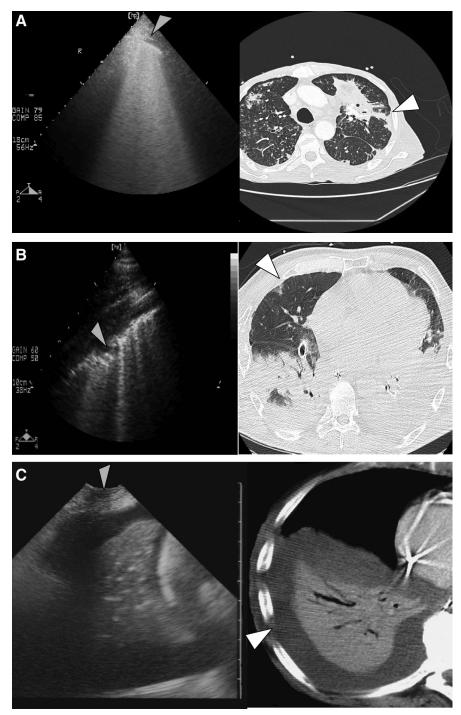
Computed tomography (CT) section and corresponding ultrasound pattern in a patient with ventilator-associated pneumonia characterized by multiple rounded CT attenuations and consolidation. A, confluent CT attenuations of the left upper lobe (*white arrow*) correspond to abutting ultrasound lung comets arising from the pleural line (*gray arrow*). B, a subpleural and intraparenchymal rounded CT attenuation of the right upper lobe (white arrow), corresponding to irregularly spaced and abutting ultrasound lung comets arising from a subpleural consolidation (*gray arrow*). C, consolidation of right lower lobe with parapneumonic pleural effusion. The white and gray arrows indicate position of the probe.
